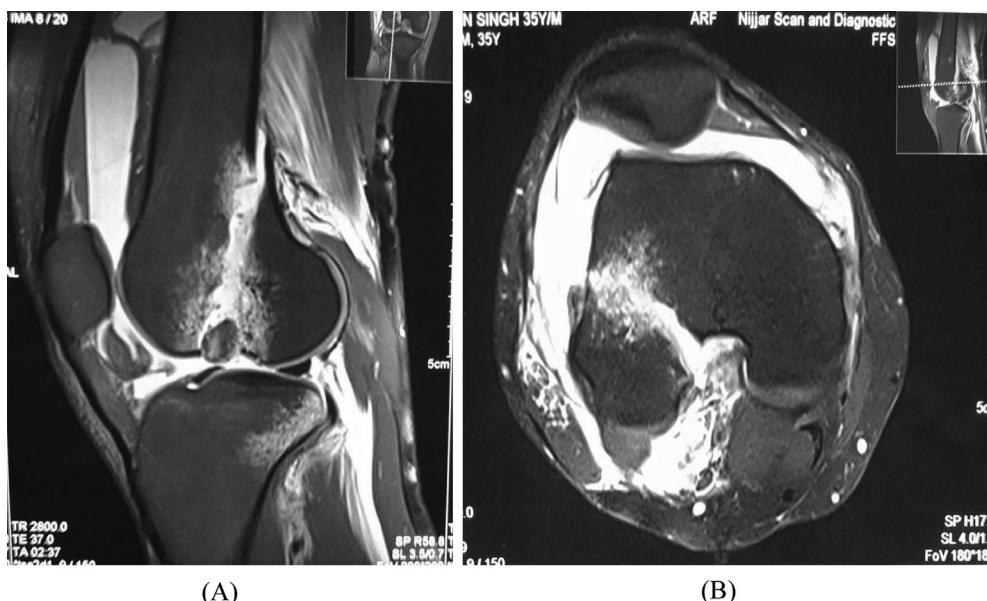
MRI images of the same case showing Hoffa fracture and associated injuries.
